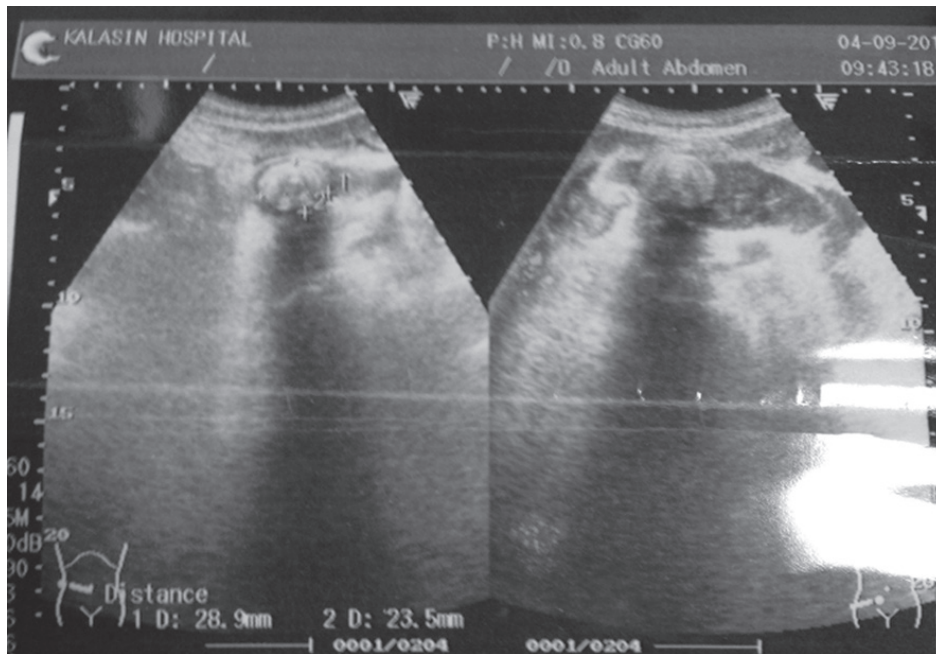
Ultrasonography shows well-defined laminated hyperechoic lesion size about 2.4x2.9 cm. in distal small bowel which is stone (arrow).
